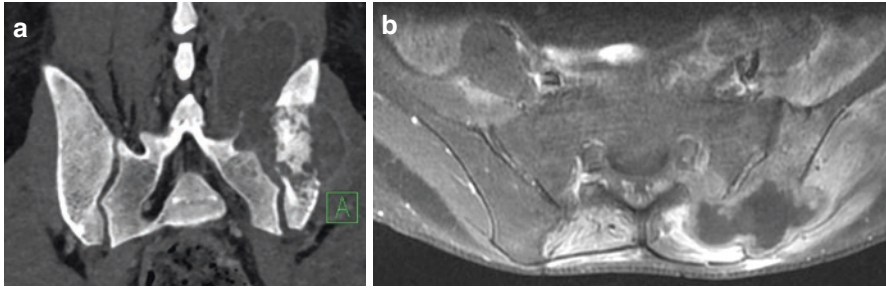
(a). CT through the sacroiliac (SI) joint reveal left iliac bone destruction with periarticular fluid collection (b) Axial T1 weighted post-contrast image MRI image of the same patient showing abnormal enhancement and destruction of the left iliac bone with peripherally enhancing collection in posterior aspect of the left SI joint
